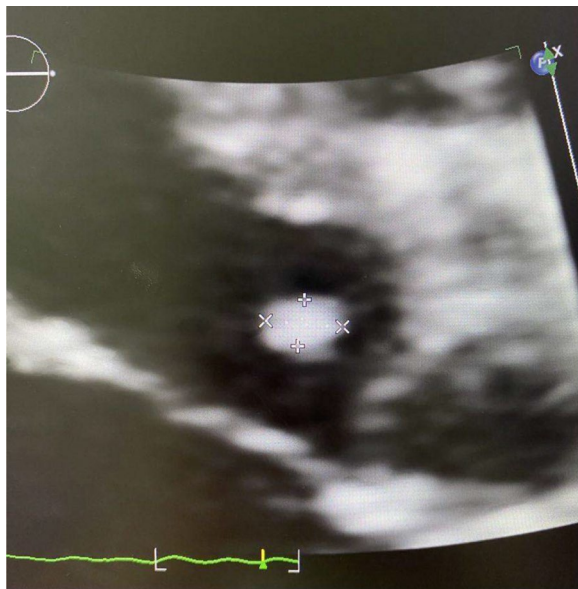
Two dimensional (2D) echocardiography. A 0.9 cm x 0.4 cm mobile aortic valve vegetation
